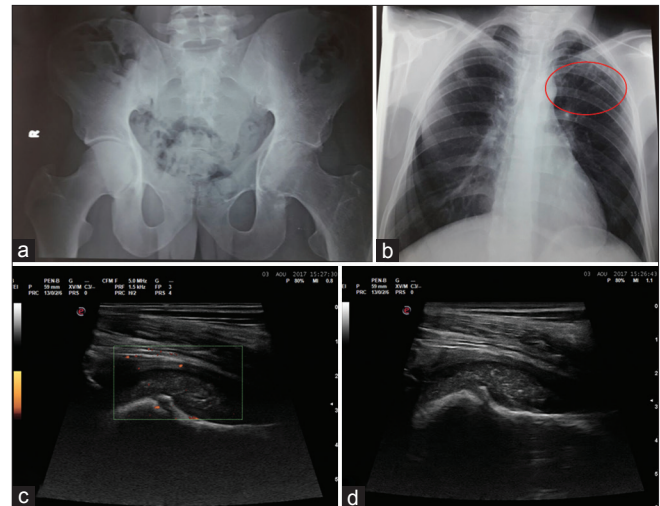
(a) Radiograph of pelvis showing left coxitis and condensation of sacroiliac joint (b) thoracic X-ray showing infiltration of summit (c and d) ultrasound imaging of the left hip with and without Doppler showing synovial hypertrophy
